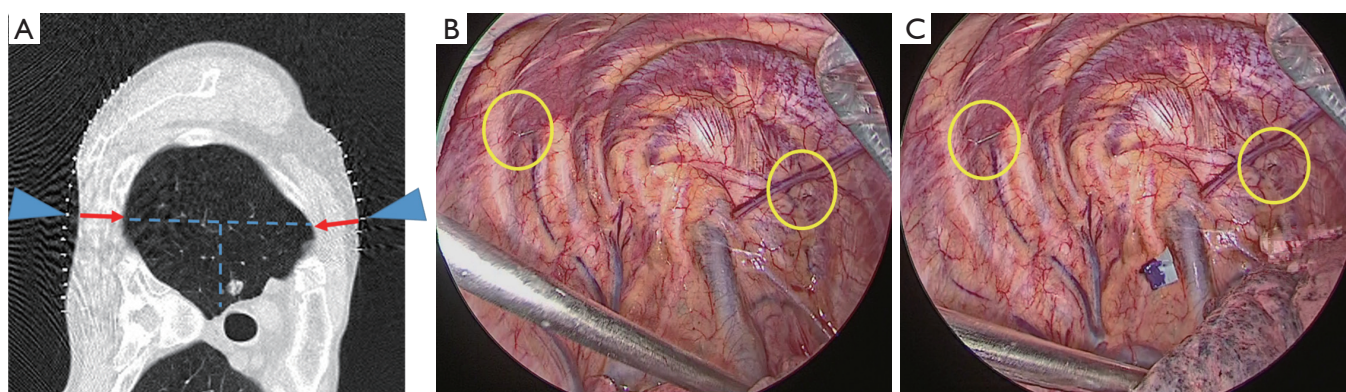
Indirect marking. (A) Preoperative marking under CT. The arrows point to the same level as the tumor and the tumor is present on the perpendicular bisector of these two points. The cutaneous marking is made on these two points. (B) During the surgery, the catheter needle is inserted into the pleural cavity from these two points. Circles indicate the tips of the needle. (C) The pleural marker is applied to the pleura above the trachea on the vertical bisector of these two points.
